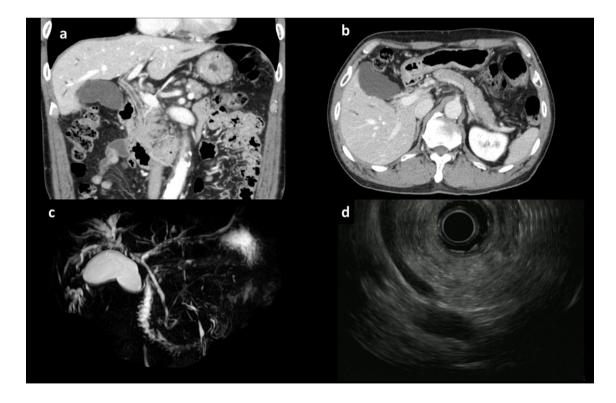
a Intrahepatic bile duct dilation and enhanced wall thickening of the extrahepatic bile duct on contrast-enhanced computed tomography. b Contrast-enhanced computed tomography showing no obvious pancreatic enlargement. c Discontinuous stenosis and dilatation
